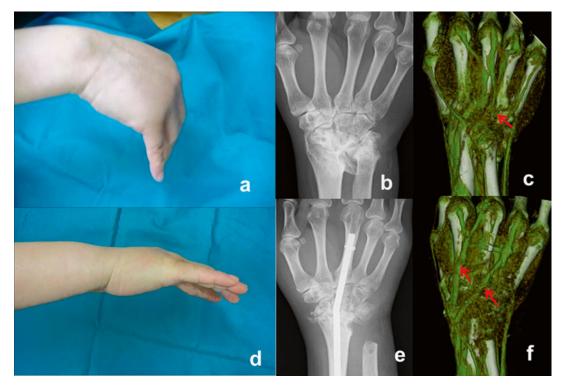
Total wrist fusion and reconstruction of multiple finger extensor tendon ruptures. A 49-year-old female patient with RA. (a) Preoperative state of the hand. (b) Preoperative radiograph. (c) Preoperative 3DCT. The
